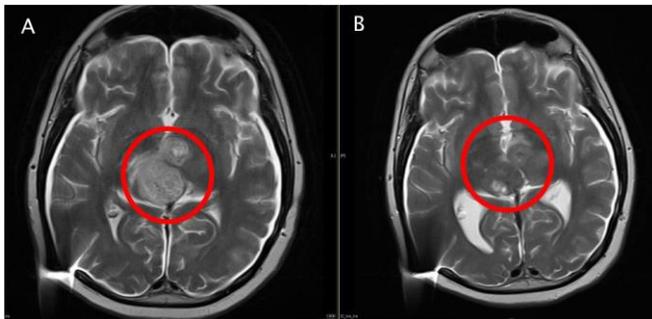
MRI of clinical response observed in a patient with DMG with H3K27M mutation treated with ACT001. (A) shows T2 weighted MRI pre study enrolment, (B) shows T2 weighted MRI after 6 months of treatment with ACT001.
